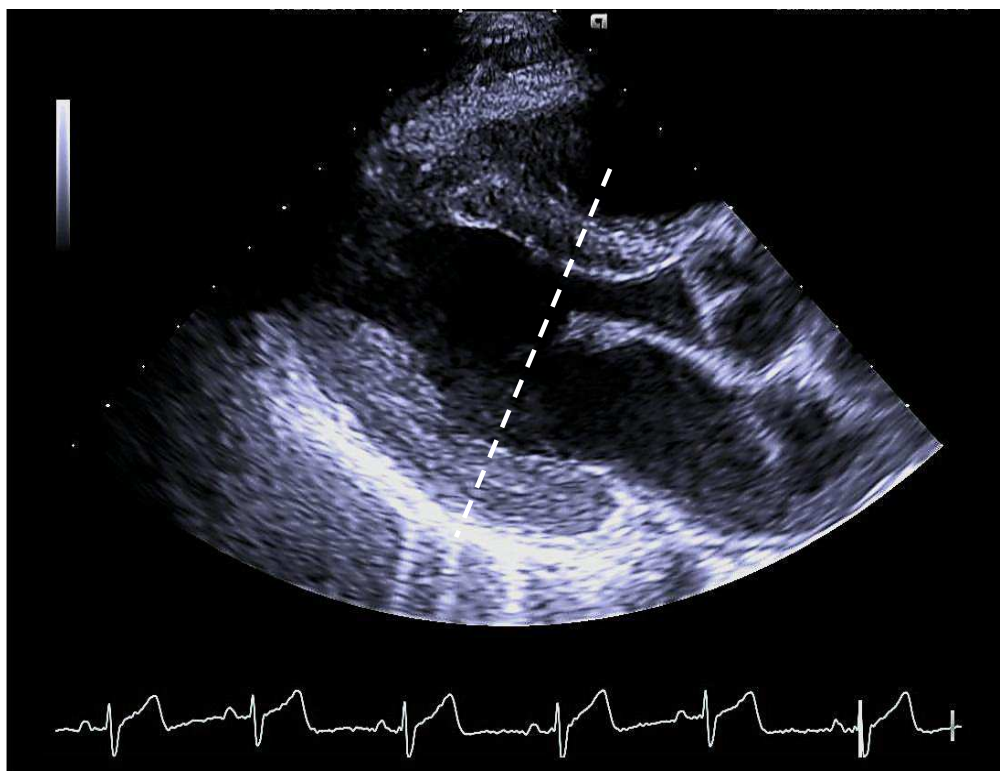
Representative example of a two-dimensional directed M-mode echocardiogram recording showing the dimension measurements employed to calculate left ventricular mass index. Note the position of the cursor in the long axis view of the left ventricle. SEPED = Septal wall thickness in end diastole. PWED = Posterior wall thickness in end diastole. SEPES = Septal wall thickness in systole. PWES = Posterior wall thickness in systole. LVEDD = Left ventricle internal diameter in end diastole. LVESD = Left ventricle internal diameter in end systole.
